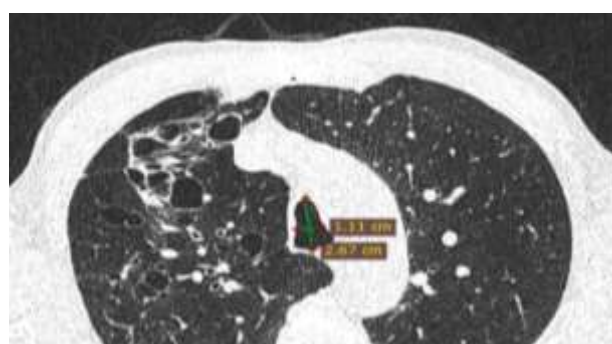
CT scan of 59 years old age male with COPD shows Saber sheath trachea with an area of cystic bronchiectasis in the right upper lobe is also seen, and he had mixed type of COPD, GOLD III score, and CT score of 7.
